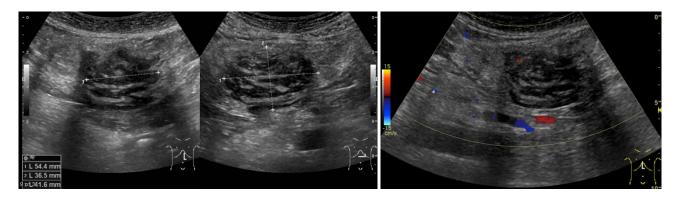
Abdominal ultrasonography shows mosaic echoic tumor at ventromedian. Tumor has poor blood flow signal and a linear hyperechoic part inside and a clear border to the surroundings.
